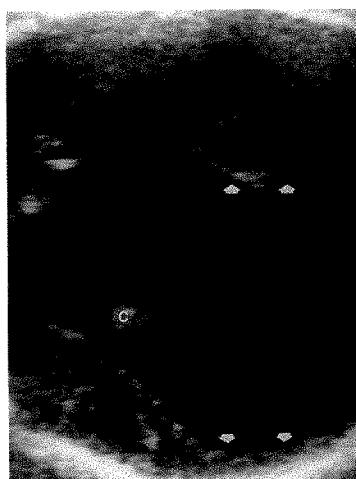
Axial prenatal sonogram at level of choroid plexus (C) in a 35-week-old fetus shows massive dilatation of dependent lateral ventricle (ventricular width marked by arrows).
